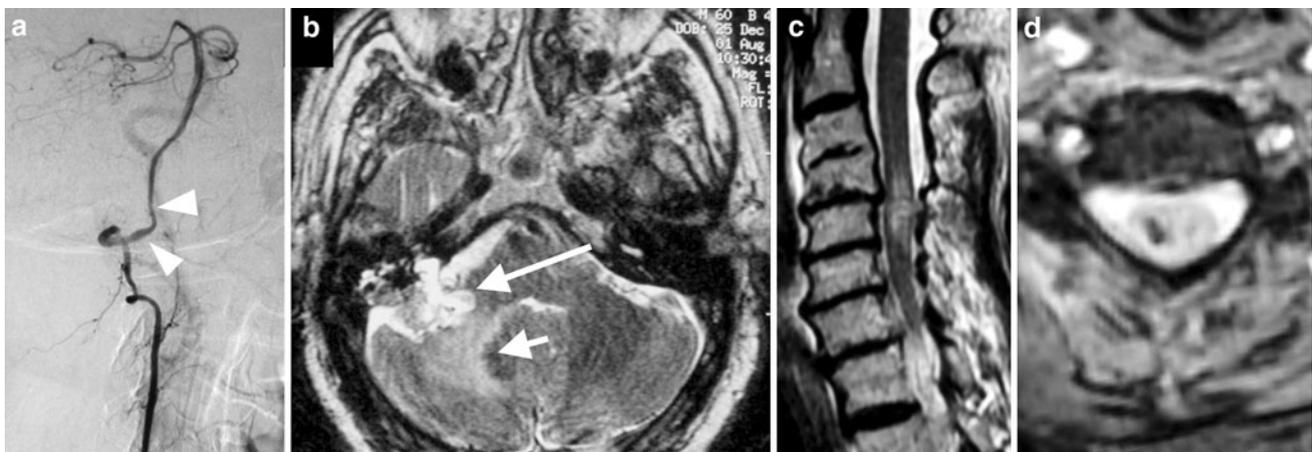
Neuroimaging of patients with RTI caused by other aetiologies than brain infarction. a Case 5, digital subtraction angiogram, anterior-posterior view, irregular narrowing of the intracranial course of right vertebral artery (*arrowheads*); b case 9, axial T2-weighted brain MRI, ponto-cerebellar angle irregular mass imprinting
